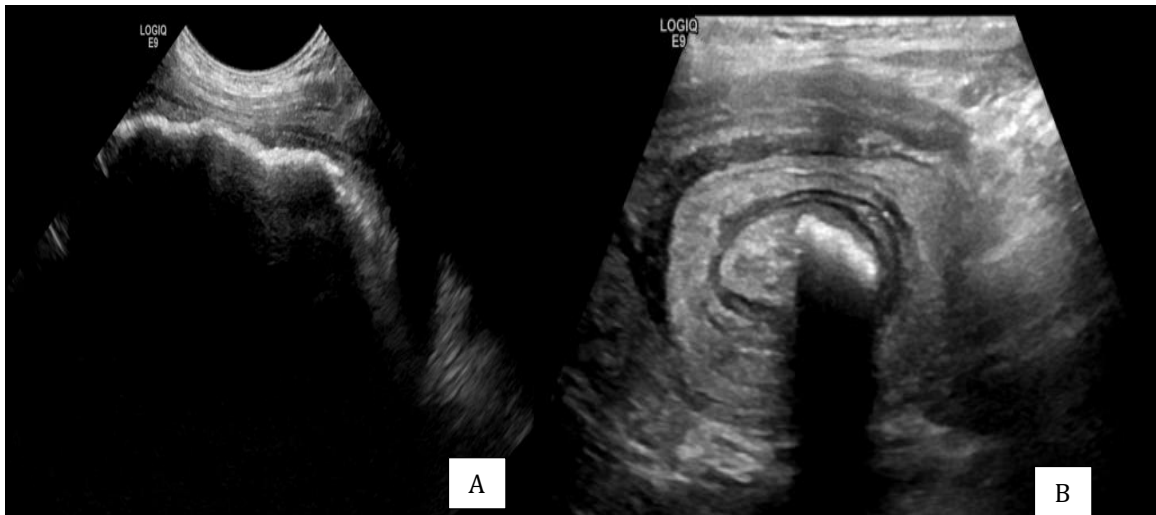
1-A :Abdominal ultrasound showing a curvilinear echogenic moving shadow in the stomach with dense posterior acoustic shadow . 1-B : Multiple target lesions are detected in the small bowel
